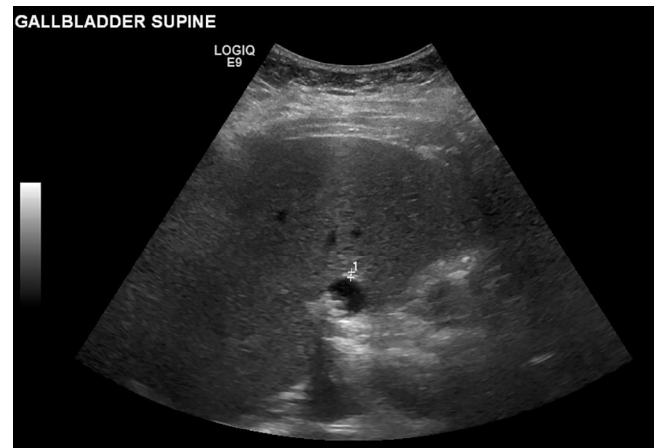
Right upper quadrant ultrasound read as a 2-mm gallbladder wall and echogenic gallstones without pericholecystic fluid, Murphy's sign, or common bile duct (CBD) dilation (3-mm CBD).
